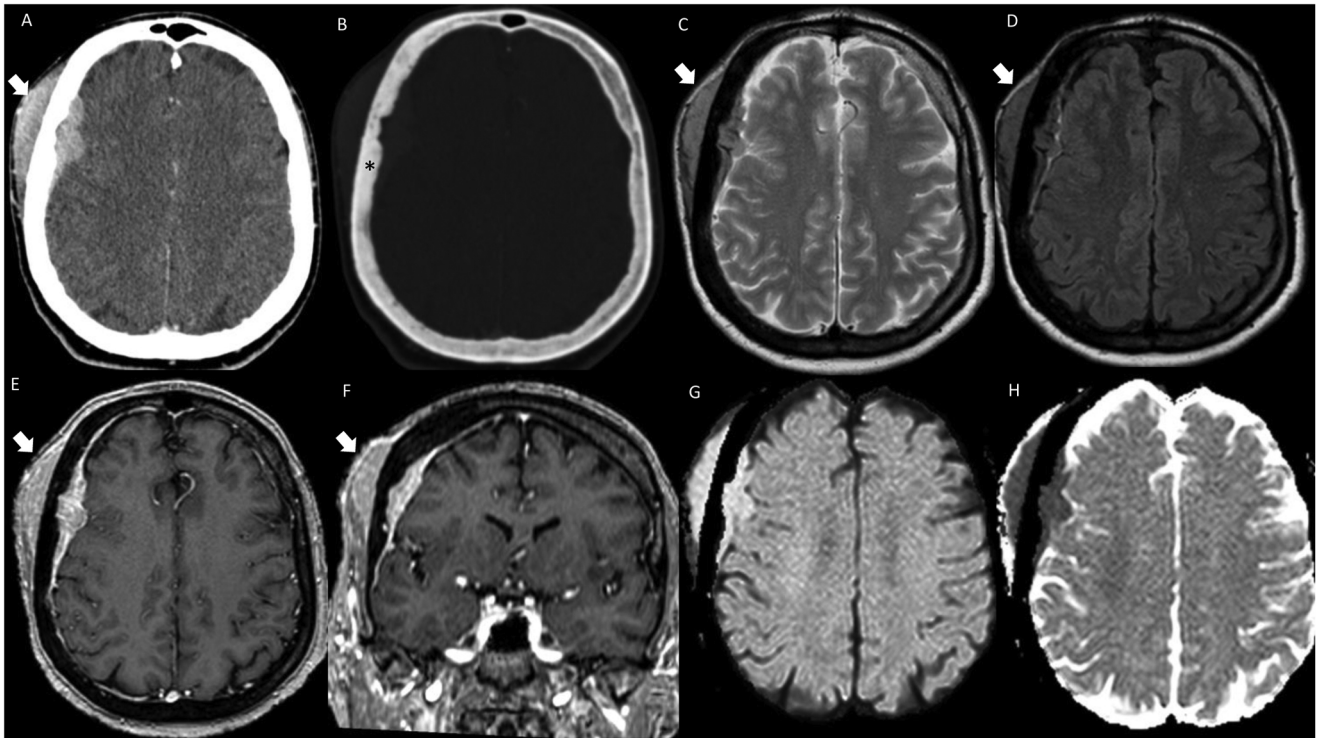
Dural MALT lymphoma. CT and MR images identify a right parietal extra-axial lesion with a wide dural implant base and marked T2 hypointensity (C), showing diffusion restriction (G and H) and intense contrast uptake (E and F). In the CT image with bone window (B), the skull bone is almost normal, only a subtle sclerosis is identified (*), although there is a large tumour component outside the diploe (arrow).
